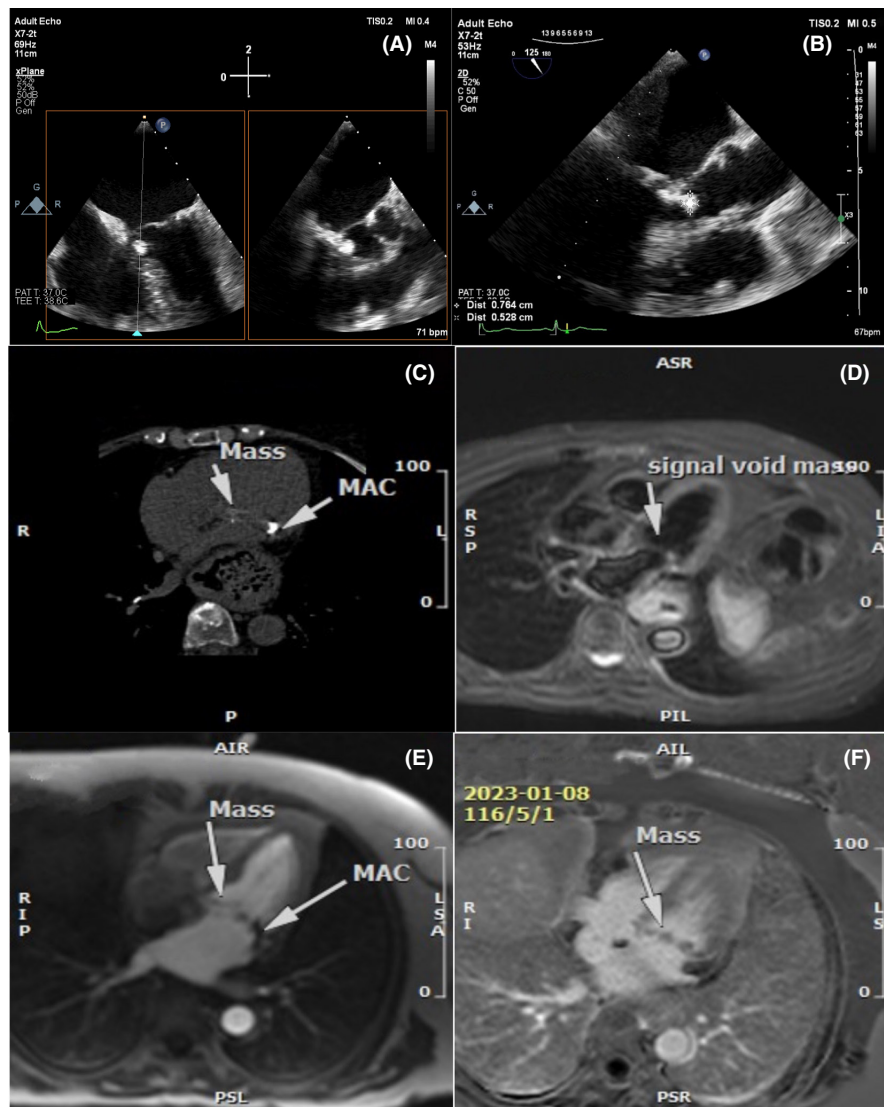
Multimodality imaging using transesophageal echocardiography (TEE), cardiac computed tomography (CT), and cardiac magnetic resonance imaging (CMR). TEE demonstrating a pedunculated mobile calcified mass (0.7×0.5 cm) attached to posterior of mitral valve (MV) annulus (A and B). Cardiac CT demonstrating mitral annular calcification (MAC) and calcified mass attached to MV annulus (C). CMR demonstrating the mass with low signal intensity on T2-weighted images (D), with no perfusion in the first pass perfusion sequences (E) and no enhancement in the late-enhancement sequences (F).
